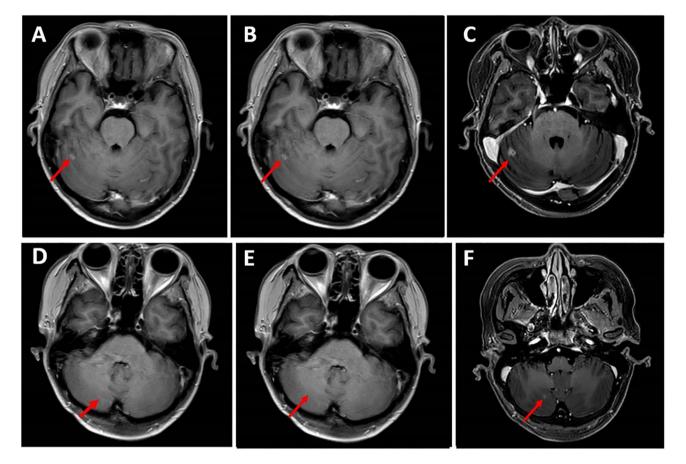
Brain MRI of the patient when the treatment was adjusted to eribulin combined with small-molecule anti-angiogenic therapy. Brain MRI demonstrates a sustained partial response in the largest lesion after treatment with utidelone and small-molecule anti-angiogenic therapy, followed by adjustment to eribulin combined with small-molecule anti-angiogenic therapy. (A and D) Baseline MRI and (B and E) efficacy evaluation showing a partial response after two cycles of treatment and (C and F) disease progression after four cycles of treatment. Metastatic size increased as follows: (A) 4.5 mm, (B) 5 mm and (C) 9.0 mm; (D) 0 mm, (E) 0 mm and (F) 2 mm. MRI, magnetic resonance imaging.
